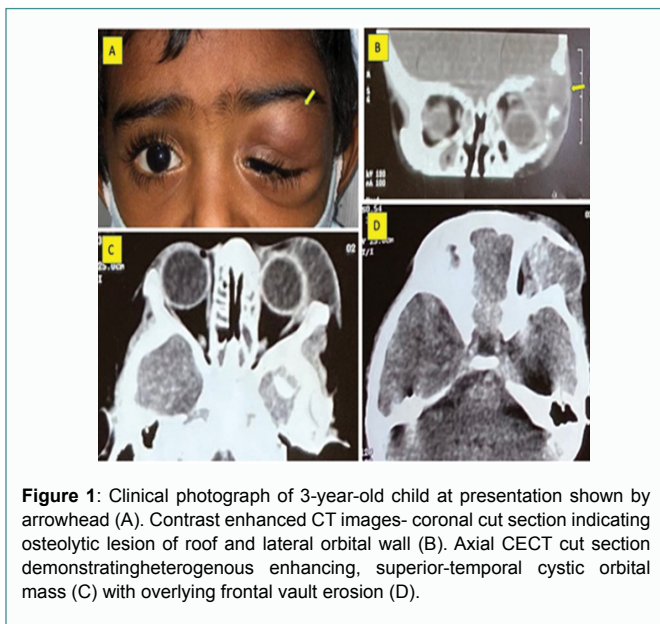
Clinical photograph of 3-year-old child at presentation shown by arrowhead (A). Contrast enhanced CT images- coronal cut section indicating osteolytic lesion of roof and lateral orbital wall (B). Axial CECT cut section demonstrating heterogenous enhancing, superior-temporal cystic orbital mass (C) with overlying frontal vault erosion (D).
